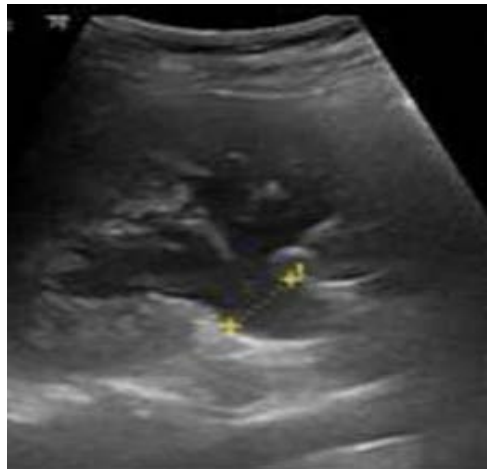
Renal and urinary tract ultrasound, coronal section. Grade II right hydronephrosis. Source: authors.
